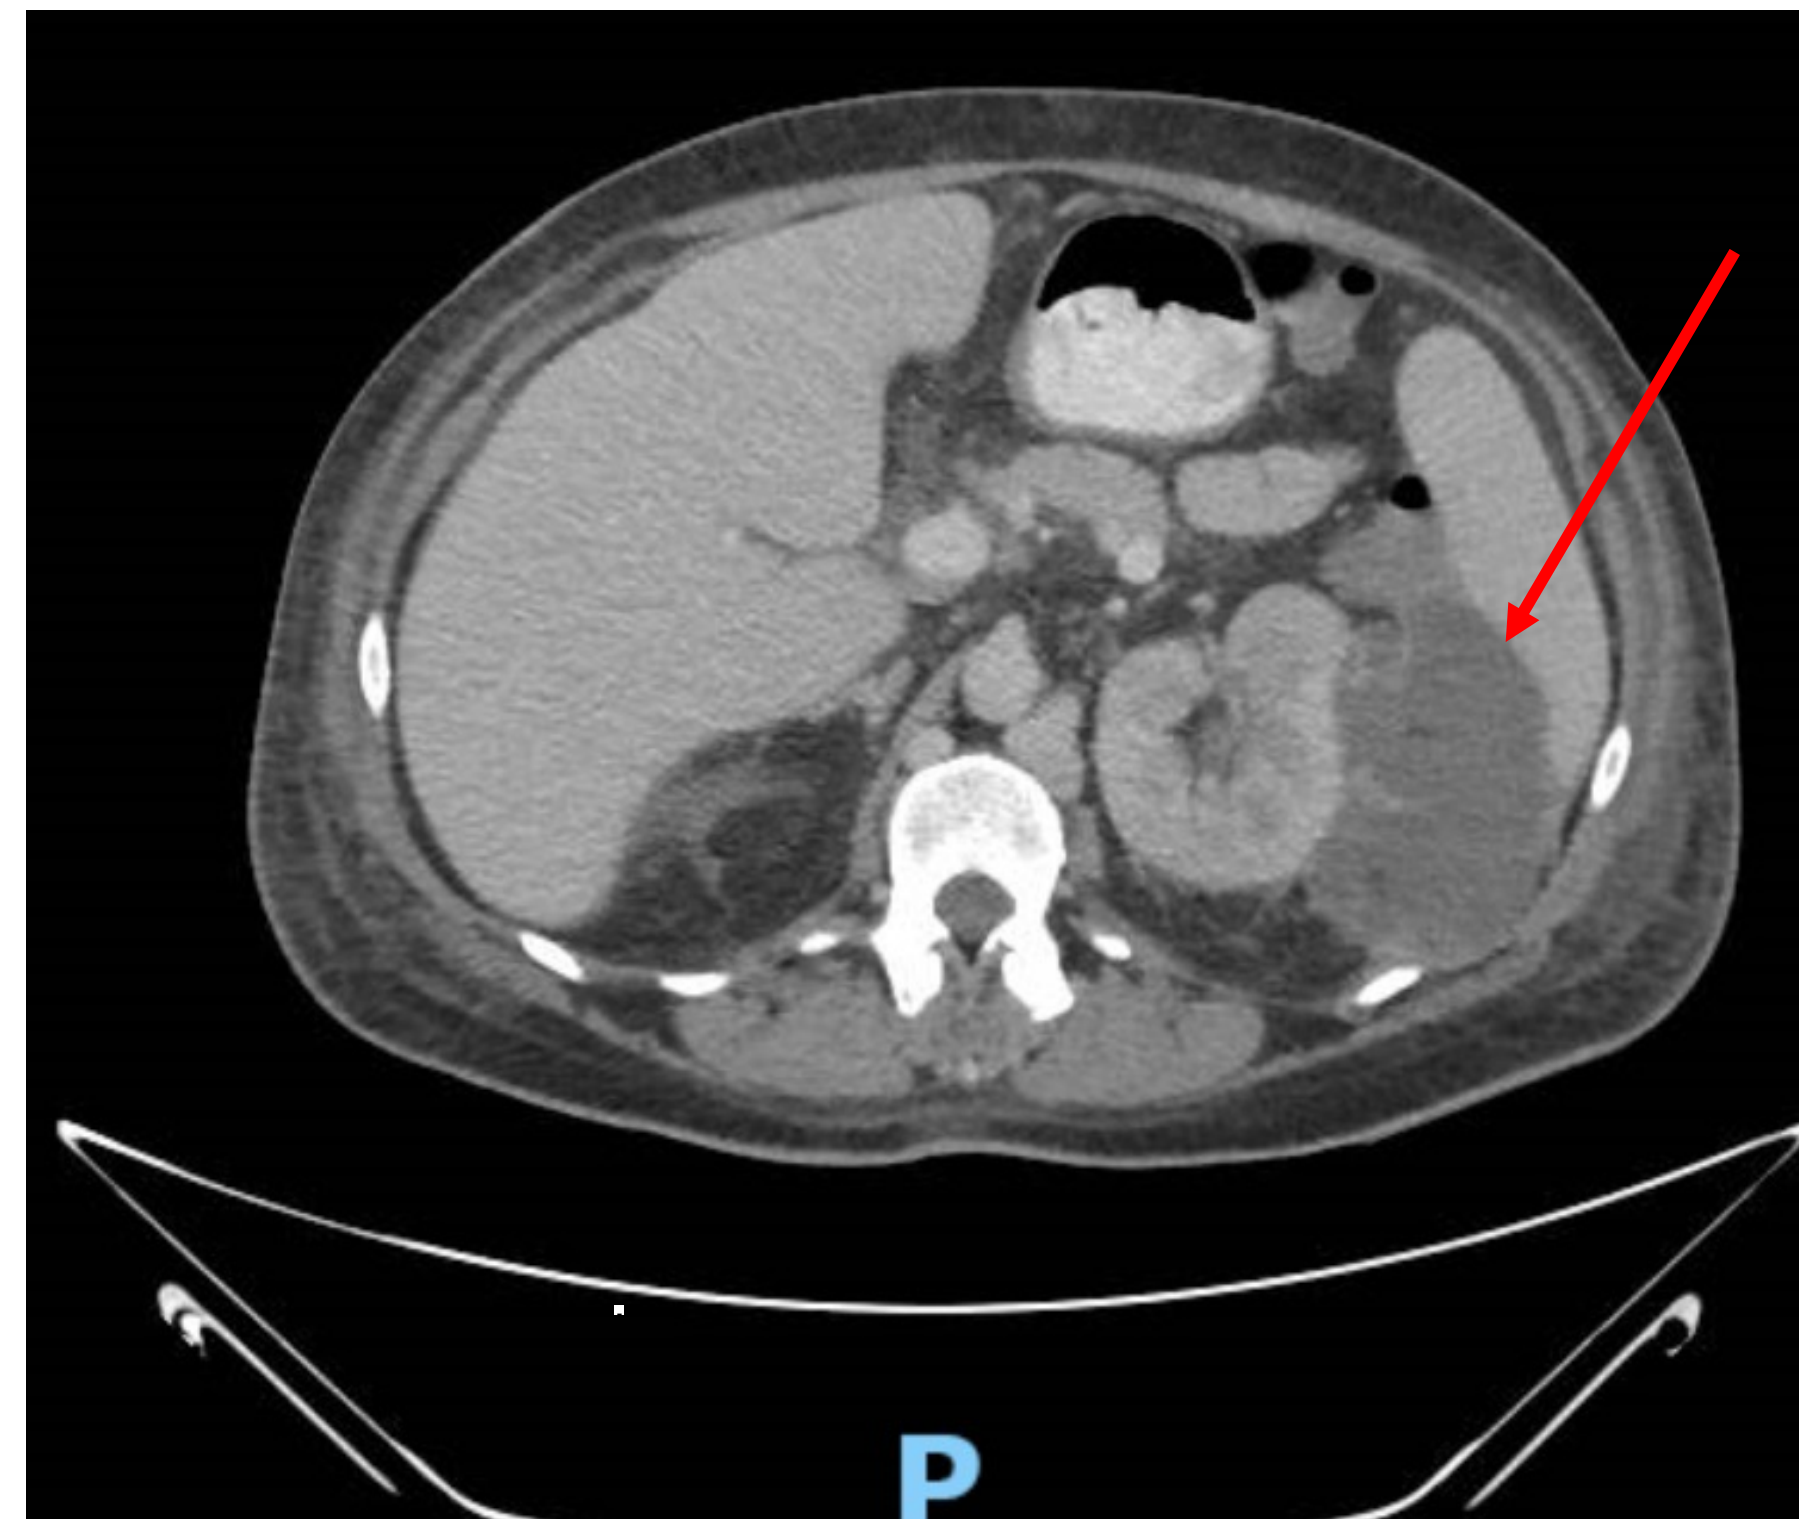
Initial CT abdomen/pelvis showing multiloculated abscess on the order of 8 cm causing mass effect on left kidney.
